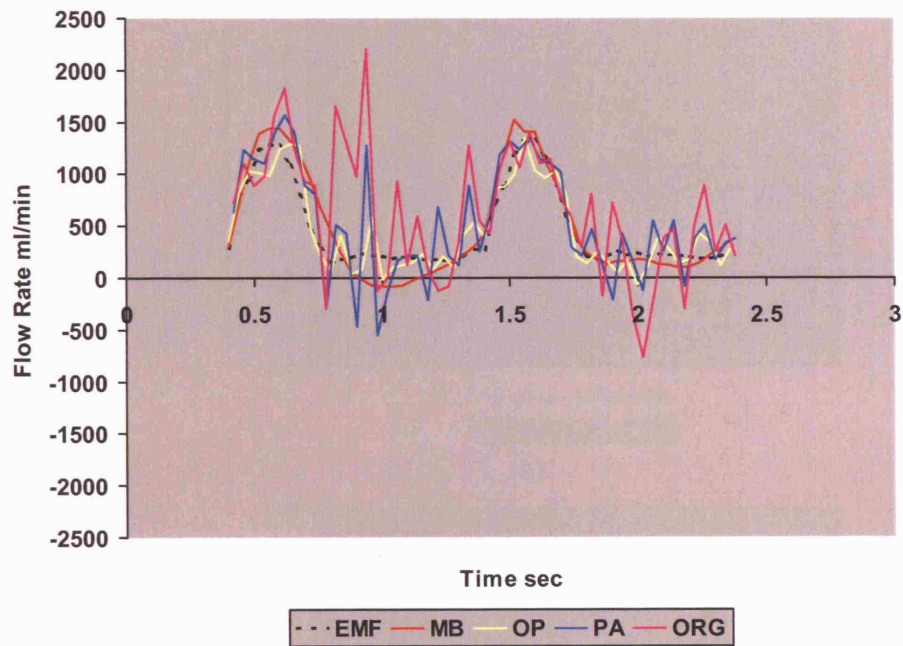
Effect of image noise: X-ray calculated and EMF waveforms for the parametric image with 10% added noise.
